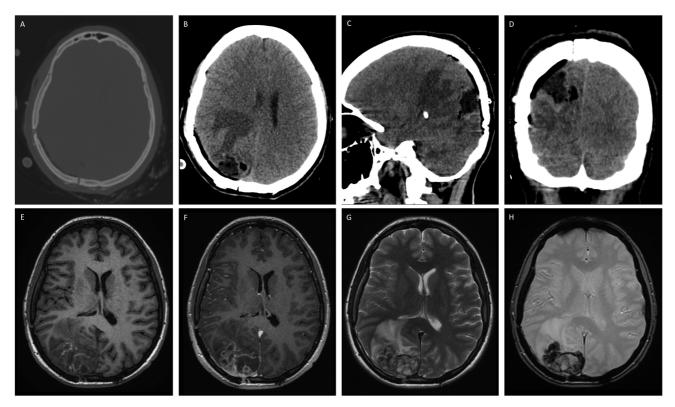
Postsurgical noncontrast cranial computed tomography. Bone window (A) with postoperative changes due to right occipitoparietal craniotomy. Axial (B), sagittal (C), and coronal (D) with right occipitoparietal surgical cavity, pneumocephalus, and hyperdense margins that could correspond to postsurgical hemorrhage or residual tumor. Contrast-enhanced magnetic resonance imaging 2 months after surgery. Axial T1-weighted imaging (T1WI) (E), contrast-enhanced T1WI (F), T2WI (G), and susceptibility-weighted imaging (SWI; H) with heterogeneous residual tumor, which has hyperintense areas on T1, hypointensity on T2 and SWI corresponding to hemorrhage; heterogeneous enhancement was observed. Adjacent vasogenic edema persists, causing displacement of the right lateral ventricle.
